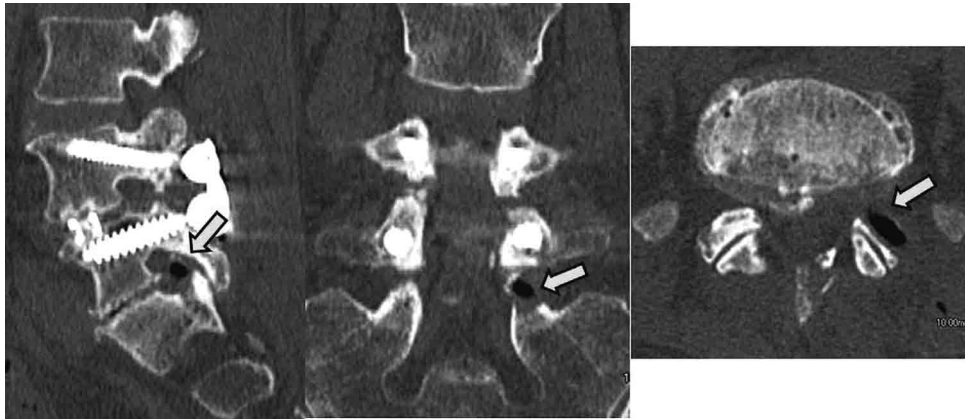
CT scans after the PELF. The CT scans show the sufficient decompression of the left foramen at L5/S (arrow).
